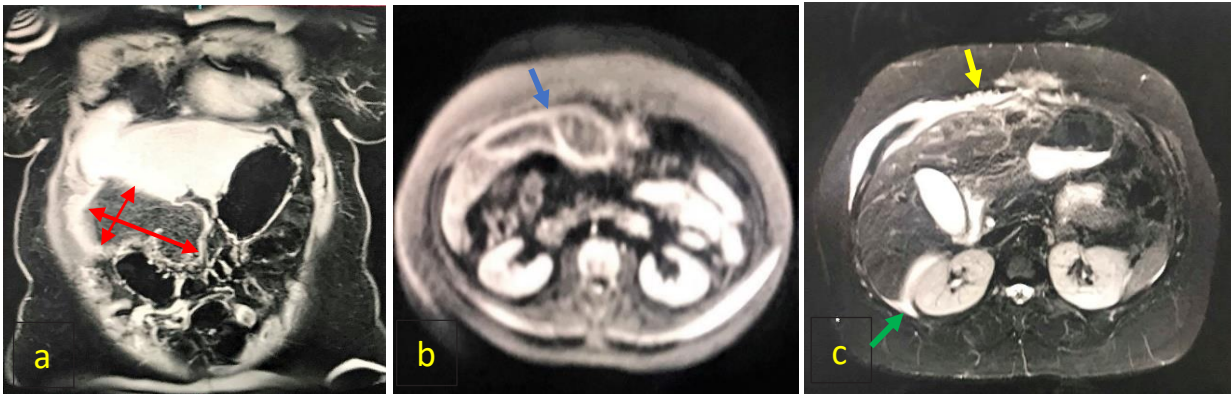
MRI with MRCP of the upper abdomen with contrast. T1 image: Well-defined lobulated mass-like lesion with fatty and edematous signals within the right upper anterior peritoneal cavity measuring 3.4 cm x 11.2 cm x 8.8 cm (red arrows). (a) DWI image. The well-defined lobulated mass lesion exhibits a thin enhancing rim (blue arrow). It is located anterior to the left hepatic lobe and superior to the transverse colon. (c) T2 TIRM image. Minimal perihepatic and perisplenic fluid (green arrow), inflammatory changes involving the right anterolateral abdominal wall with moderate edema of the overlying subcutaneous layer (yellow arrow).
